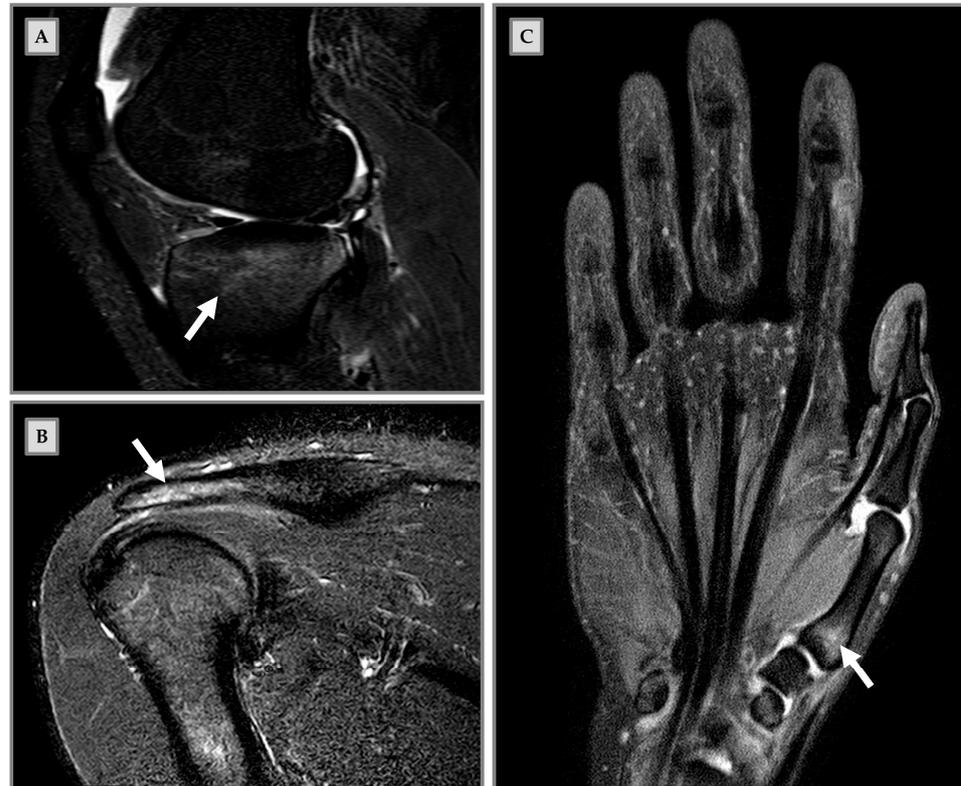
Bone marrow edema (BME) on magnetic resonance imaging (MRI) in clinical cases of nonprofessional athletes. (A) Male patient, 18-years old, art martial player. The patient had been in pain for three weeks during sports activities, elicited by kicking in the air. MRI sagittal short-tau inversion-recovery (STIR) shows BME (arrow) at the tibial plate. (B) Male patient, 20 years old, padel player. One-month pain and hypersensitivity during sports activity; he continued to train until functional impairment development. MRI coronal STIR shows BME (arrow) at the humerus diaphysis and the distal acromion end. (C) Female patient, 29 years old, volleyball player. The patient resumed intense physical activity after a period of no training. She presented pain onset during sports activity and functional impairment. MRI coronal STIR shows BME (arrow) at the first metacarpal bone.
